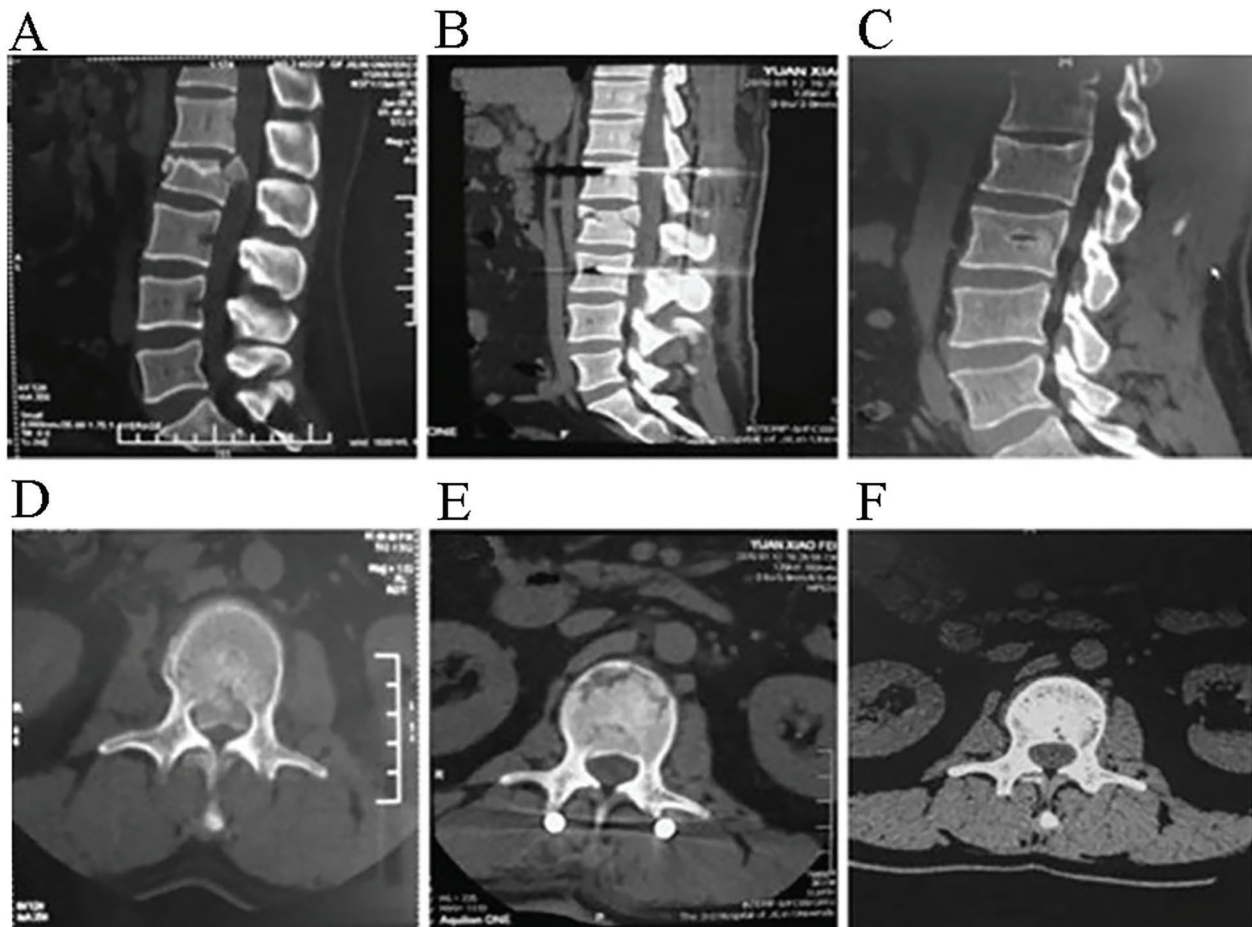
CT images showing significant restoration of the posterior and anterior vertebral height after surgery (B) and 2 years postoperatively (C), compared with the preoperative image (A). Postoperative axial CT image (E) showing significant canal decompression compared with the preoperative image (D). F, postoperative image two years after surgery showing that the canal was still enlarged.
